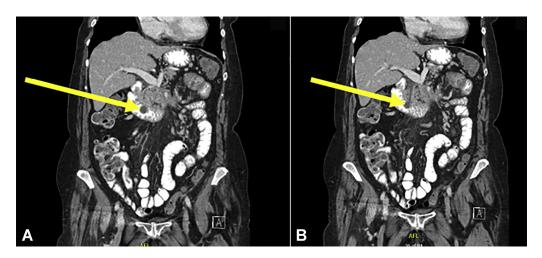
Coronal view of a CT scan of the abdomen and pelvis. A, Arrow showing type III choledochal cyst. B, Arrow showing type III choledochal cyst and common bile duct.
